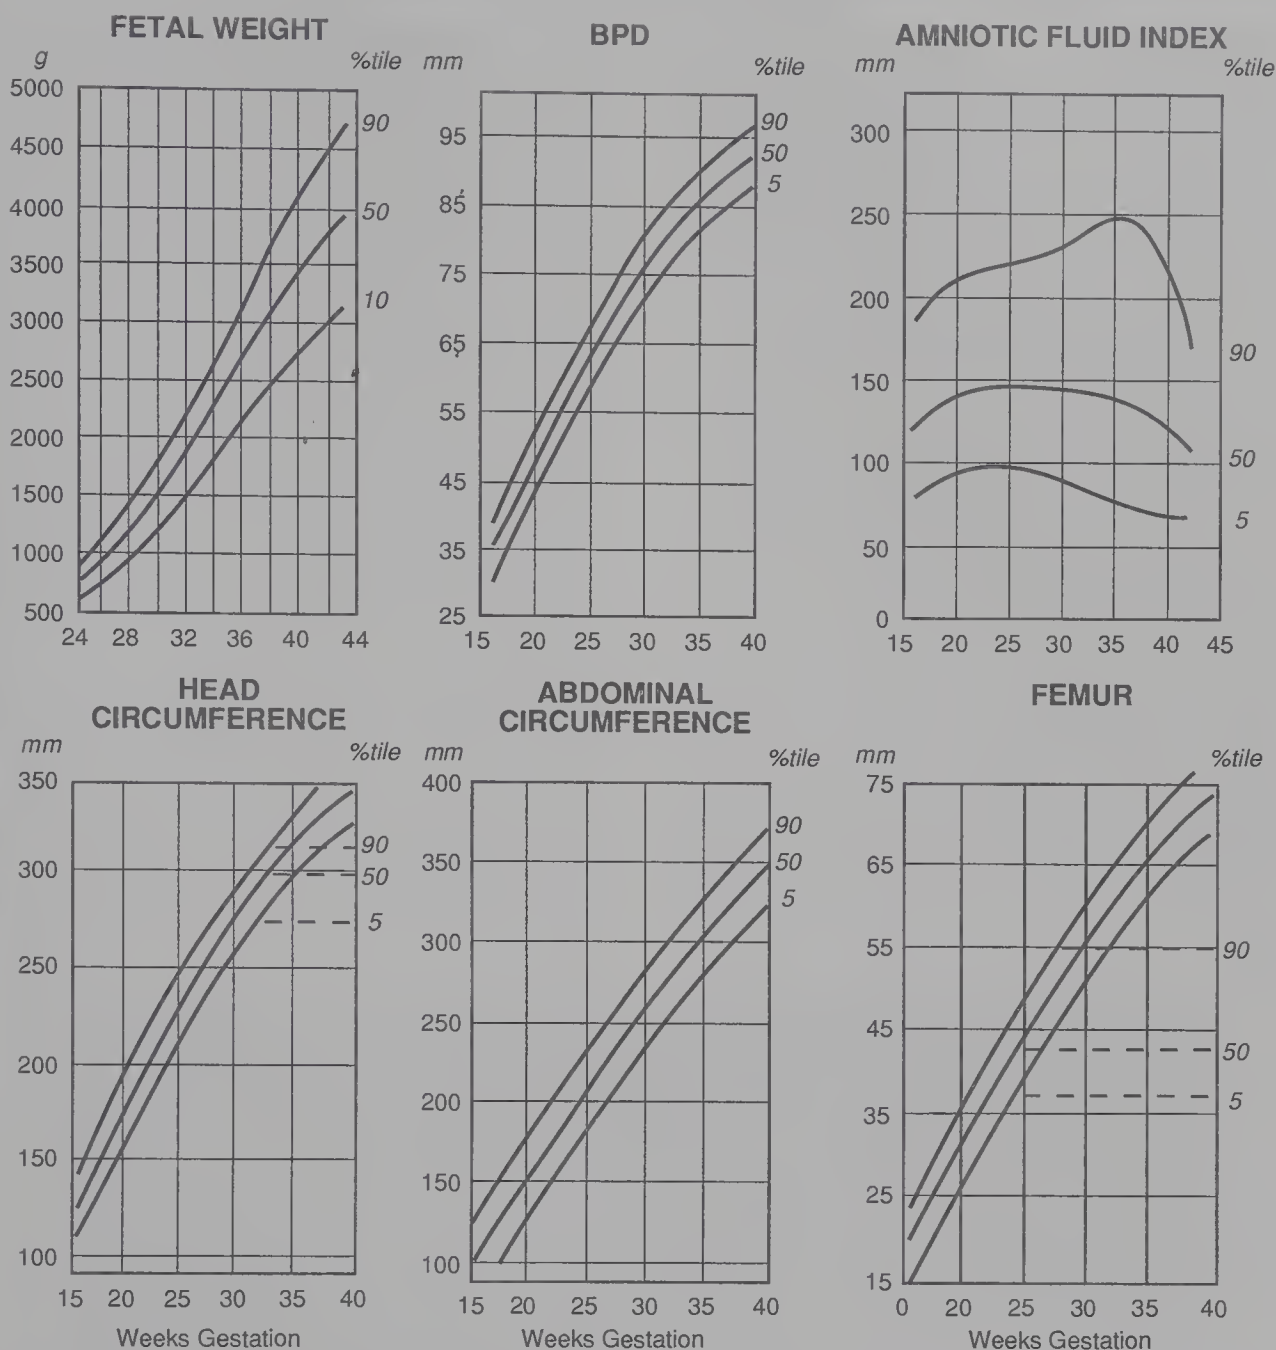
Fetal growth record and amniotic fluid index for longitudinal sonographic examinations at the University of California San Diego. Fetal weight is calculated by the formula of Warsof and associates (25).
